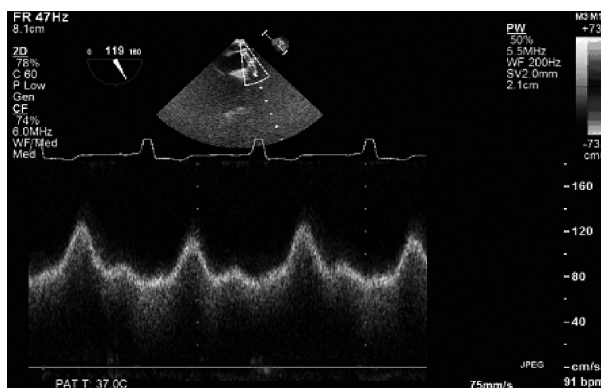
PW Doppler in the outflow cannula in the Ascending Aortic in a MOE long-axis view at a multiplane angle of 120° .
